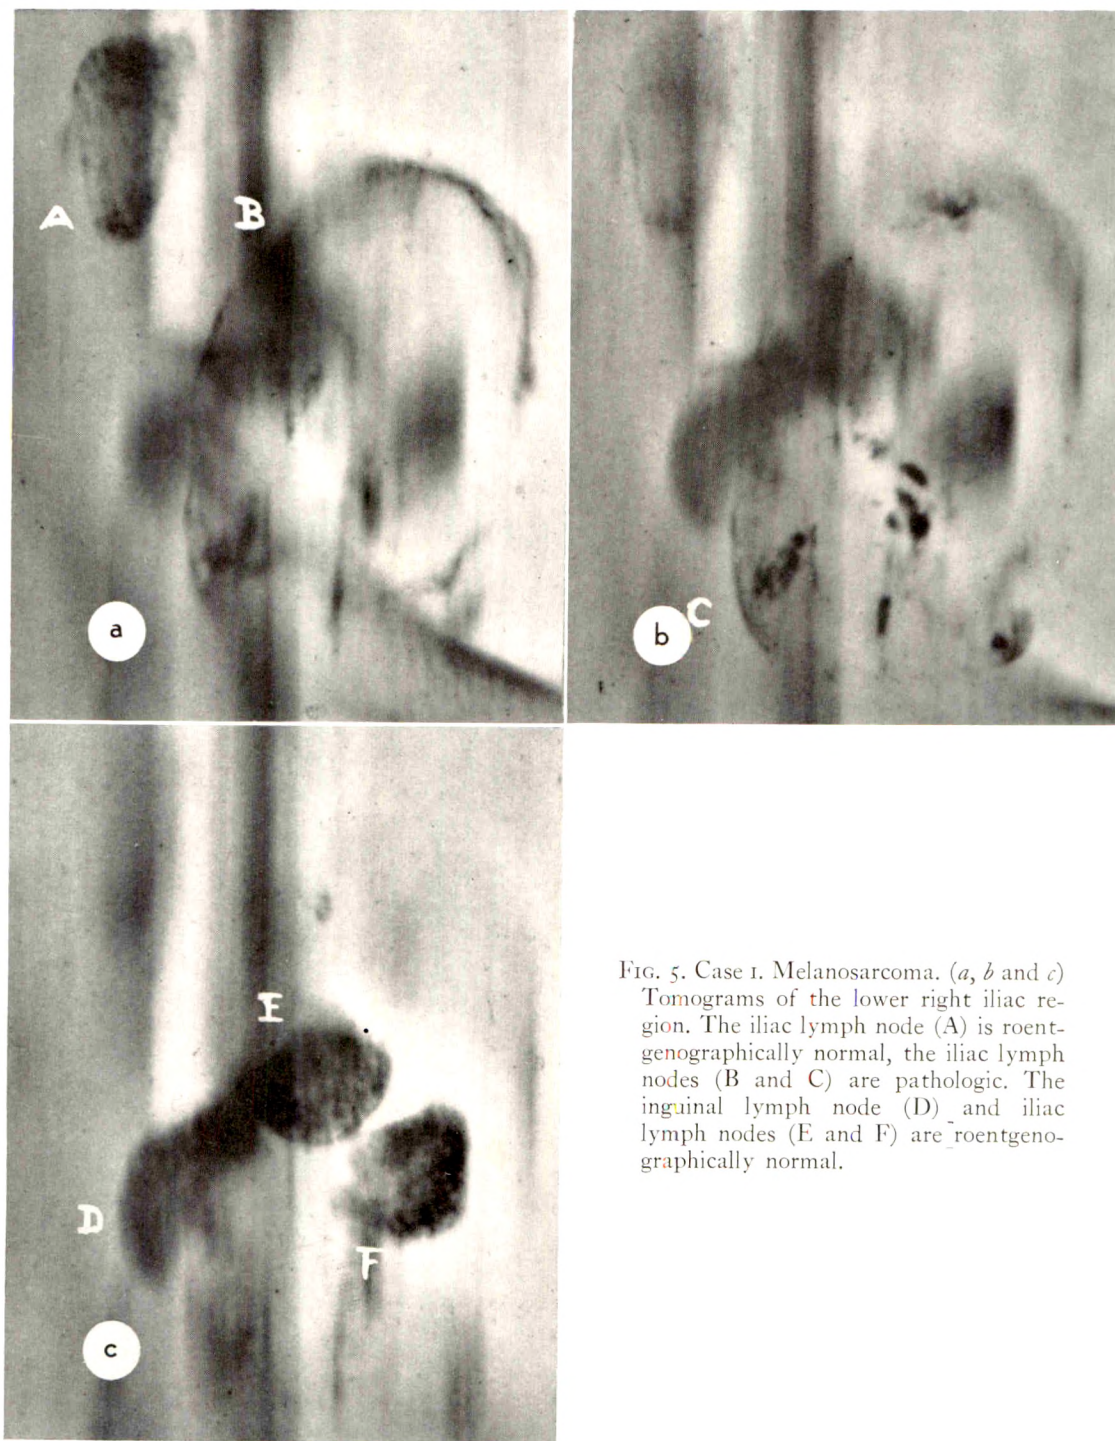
Case 1. Melanosarcoma. (*a*, *b* and *c*) Tomograms of the lower right iliac region. The iliac lymph node (A) is roentgenographically normal, the iliac lymph nodes (B and C) are pathologic. The inguinal lymph node (D) and iliac lymph nodes (E and F) are roentgenographically normal.
